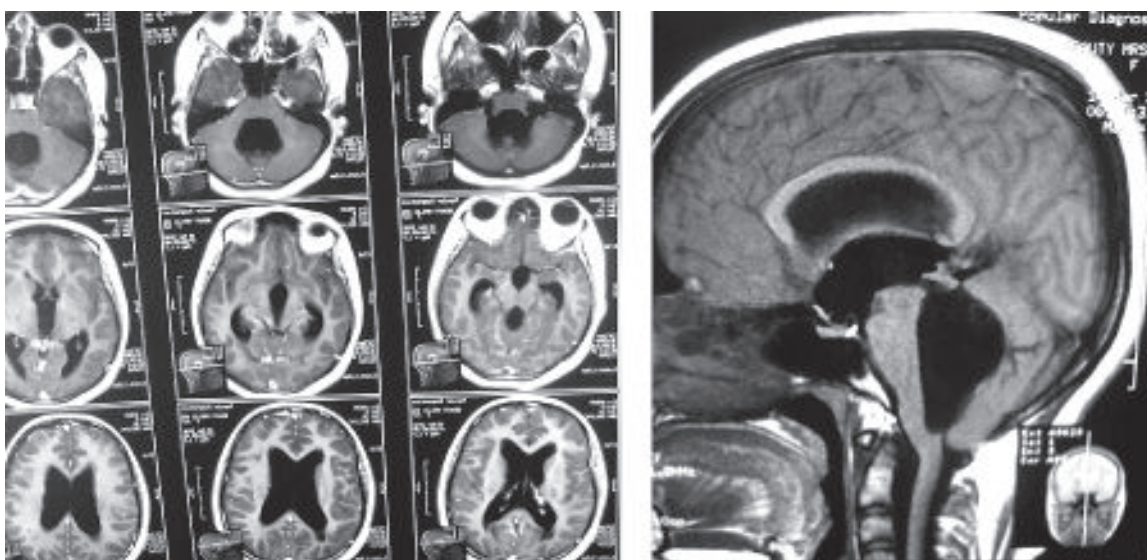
MRI of brain contrast-enhanced T1-weighted axial and sagittal image on admission showed dilatation of both lateral, third and fourth ventricles, no obstructive lesion.
